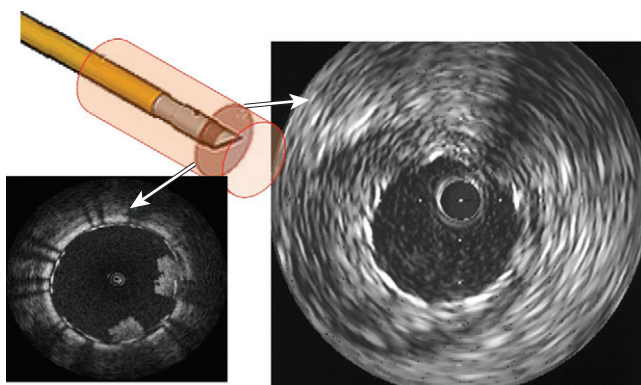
Intravenous ultrasound (IVUS) catheter has either rotating imaging core or multiple microtransducers at tip to generate IVUS image (*right*). Optical coherence tomographic imaging uses a rotating core of the imaging fibers to generate image (*left*).
